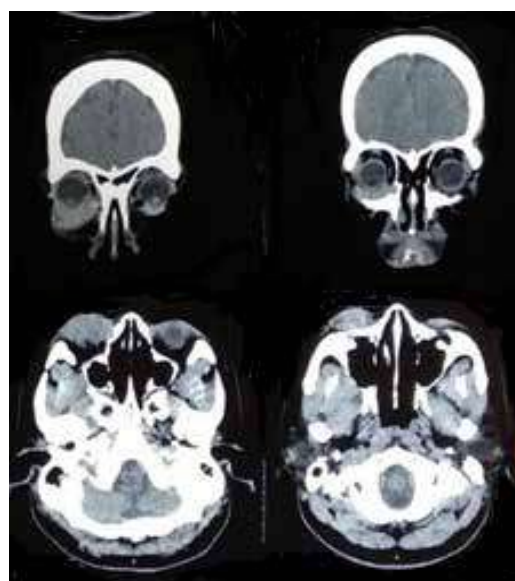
CT-Scan Orbital. Enhancing solid mass size +/- 3,2x1,9x1,75 cm on right-sided inferior palpebra and +/- 2,6 x 0,8 x 1,2 cm on left-sided inferior palpebra, pressing bulb oculi to posterior, suspicious bilateral malignant mass of inferior palpebra, no extended intraocular lesion to left and right sides, submandibular lymphadenopathy.
